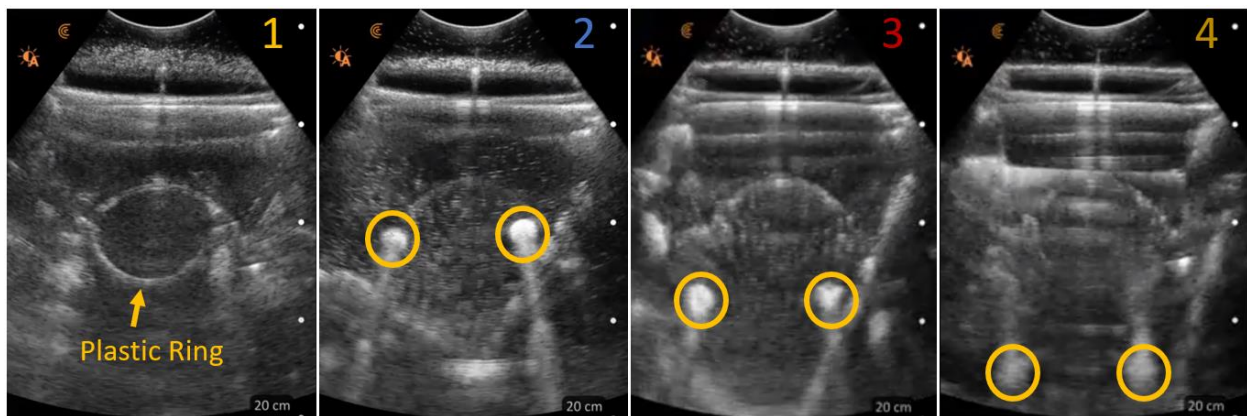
Highlighted Features of Each Ultrasound Image
